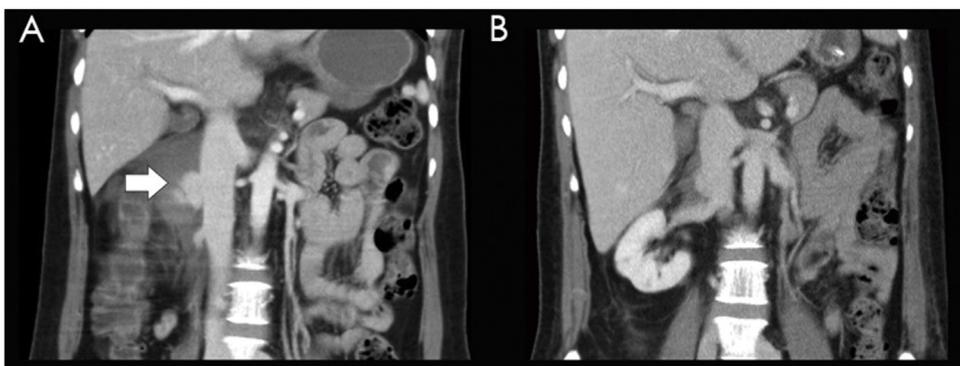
Coronal view of a computed tomography scan of a vena caval trauma. (A) A suprarenal vena caval trauma with pseudoaneurysm formation (arrow). (B) After conservative management, pseudoaneurysm regression was observed.
